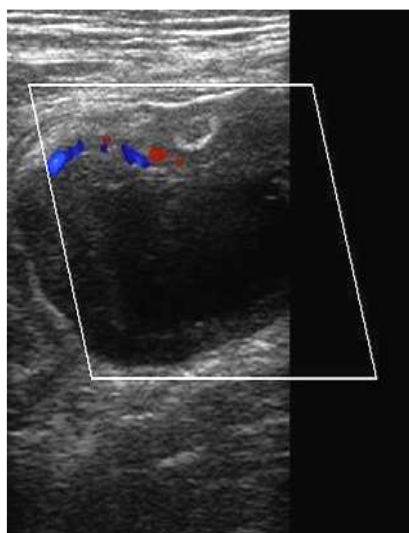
Appendicular abscess - localized fluid collection was seen which is walled off by adjacent greater omentum and small-bowel loops. When a complex, hypo echoic mass adjacent to cecum or appendix was present, even though the inflamed appendix is not visualized, appendicular abscess will be suggestive. Color Doppler study shows increased peripheral vascularity.
